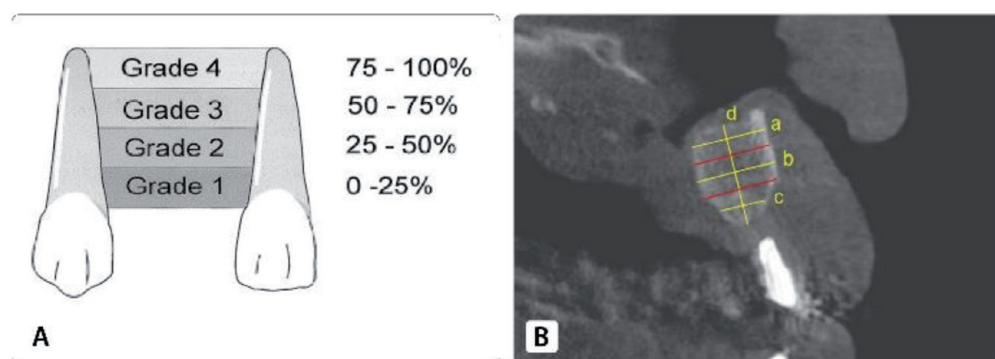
Evaluation bone formation. A. Using periapical radiograph with Enermark scale. B. Using cone beam computed tomography (CBCT).
